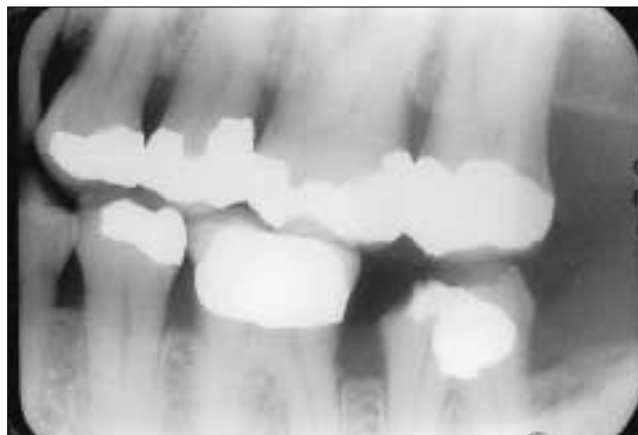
Bitewing radiographic image of mandibular second molar tooth from which a crown dislodged.
